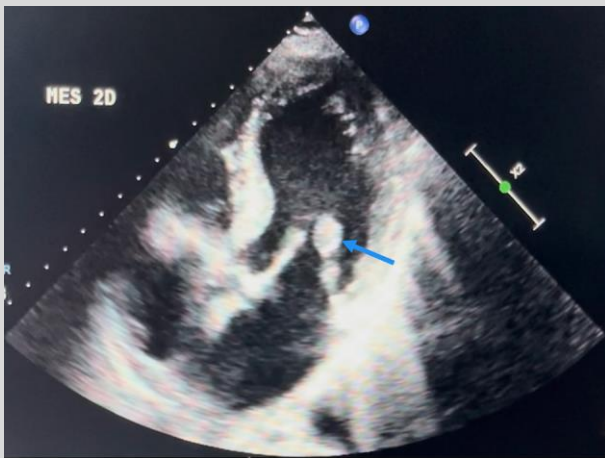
Apical five-chamber view during diastole showing an element attached to the anterolateral mitral leaflet identified as a portion of the papillary head (blue arrow).
